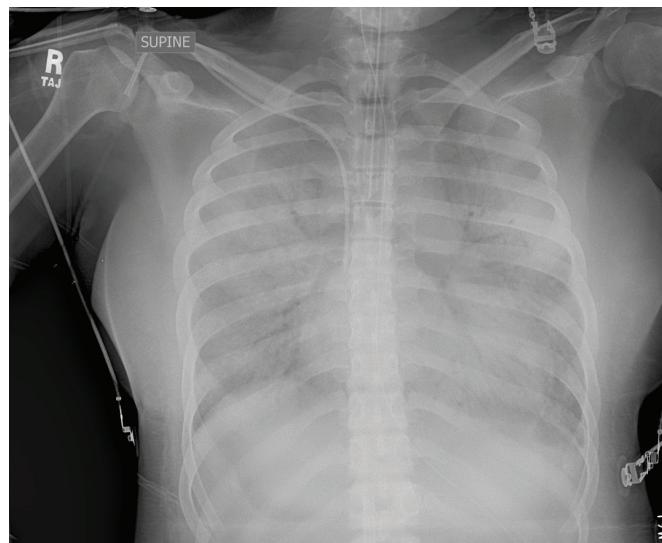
Chest x-ray at the time of the patient’s admission to our center just prior to extracorporeal membrane oxygenation.
